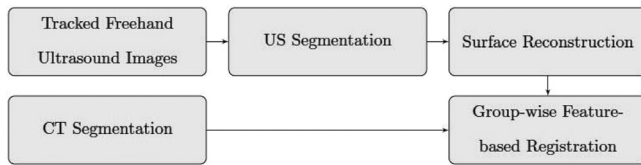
The workflow of the proposed methodology. Ultrasound images are segmented to identify vertebrae surfaces. By using the tracking information, a 3D representation of vertebrae surface is generated. Using segmented CT volume, a point-based registration method is applied to register the two point sets.
